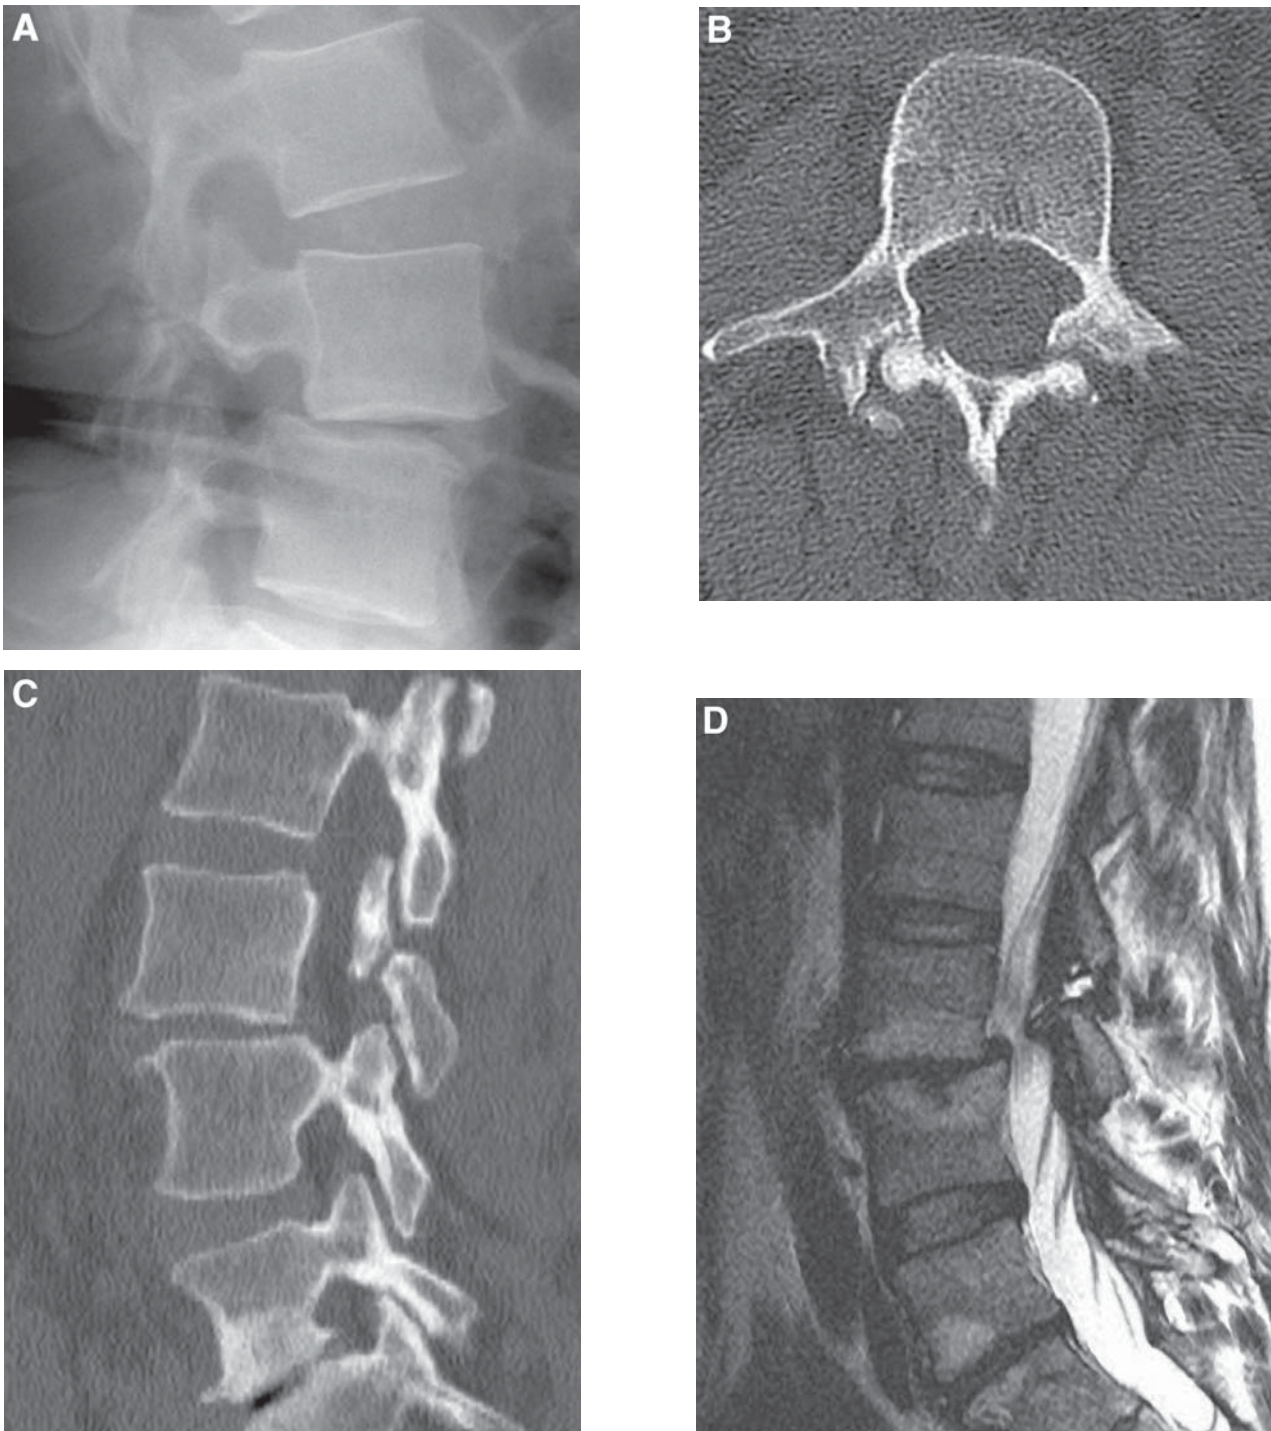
Lateral radiograph (A) and axial CT (B) reveal obvious interruption of the pars interarticularis at L3 bilaterally. There is associated disc degeneration at L3–4 with grade 1 spondylolisthesis. (C) Sagittal CT reformation again demonstrates the spondylolysis. The actual bony defect may be difficult to detect on MR images, as in this case. (D) Sagittal T2 shows reactive edema, which is indirect evidence of instability at that level.
